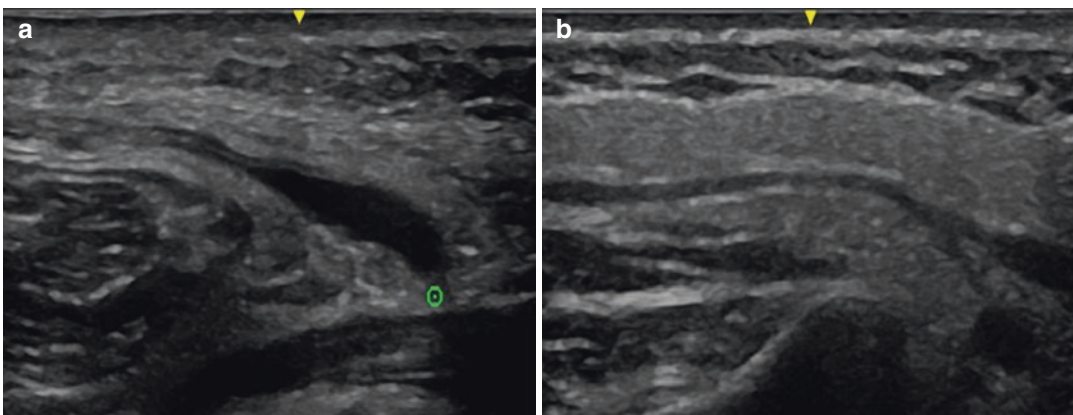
Transverse view on ultrasound of a dilated right Stensen's duct with obstruction at the ostium (a); a left dilated Stensen's duct with thickened duct wall (b)
